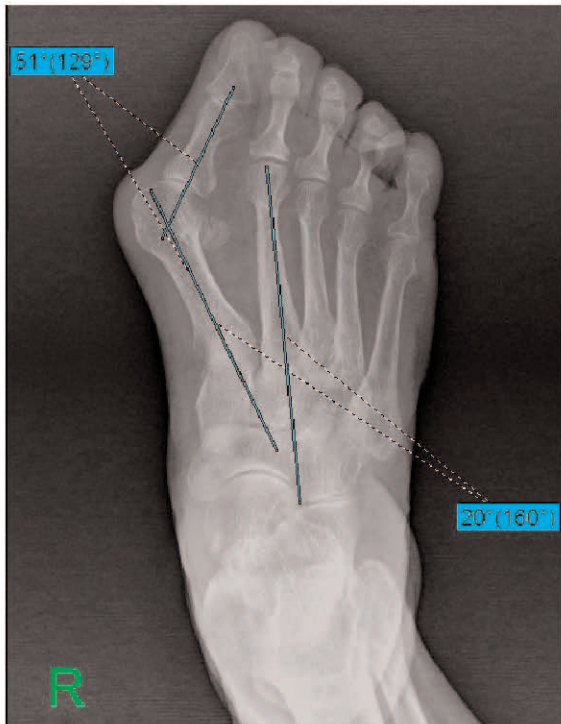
Preoperative antero-posterior weight-bearing x-ray radiography of a 62-year-old woman. Hallux valgus and intermetatarsal angles were 51° and 20°, respectively.
